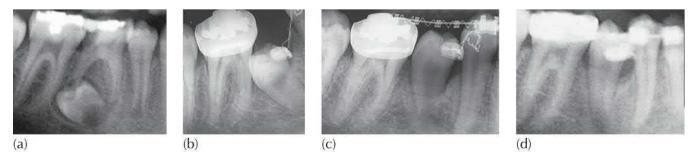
(a) The mandibular second premolar is very late developing both in absolute terms and relative to the other permanent teeth. It is strongly distally tipped. (b) A year later, periapical view shows bonding of an attachment was achieved only after wide exposure and removal of much bone to achieve access for bonding an attachment. (c) A follow-up radiograph shows improvement in the position of the tooth, but crestal bone height is deficient. (d) The relevant section of the panoramic view of the final stages of treatment clearly shows the reduced periodontal prognosis of the right mandibular second premolar.
